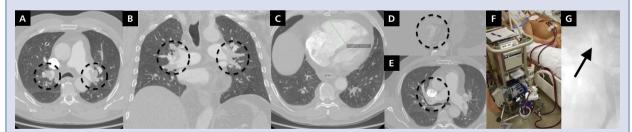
A, B. Massive pulmonary embolism in the main pulmonary arteries (computed tomography); C. Right ventricle dilatation in pulmonary embolism; D. Thrombus in vena cava inferior; E. Thrombus in vena cava superior; F. Central cannulation (trans-thoracic) venoarterial extracorporeal membrane oxygenation (VA-ECMO); G. TRAPEASE® permanent vena cava inferior filter (CORDIS USA)
